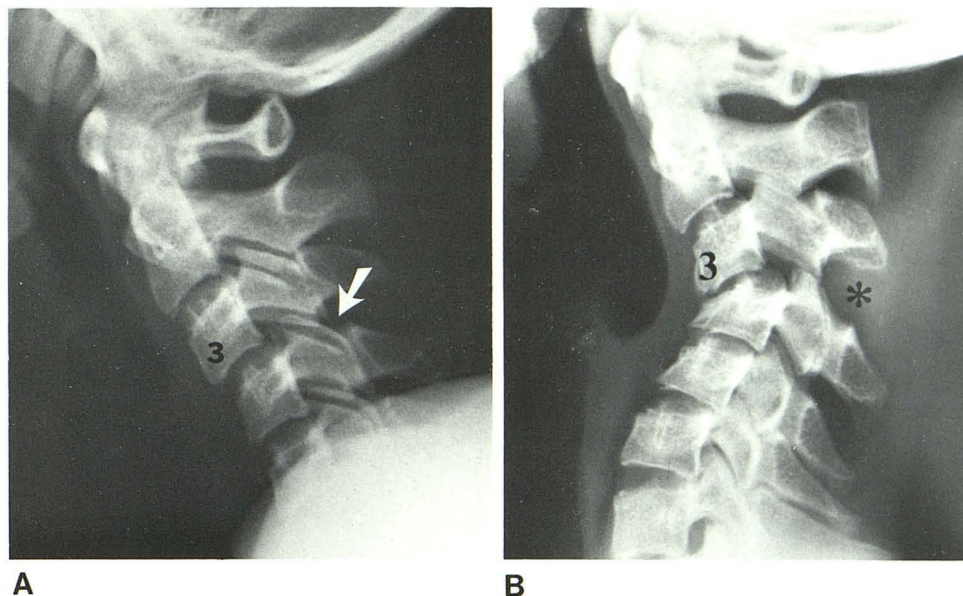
Anterior subluxation of C4 on C5 with delayed instability. A, Initial neutral lateral radiograph. Obvious signs of subluxation. Patient was treated for "cervical sprain" with soft collar until acute symptoms subsided. B, 3 months later. Radiograph obtained because of chronic complaints. Greater degree of subluxation. (Reprinted from [4].)
